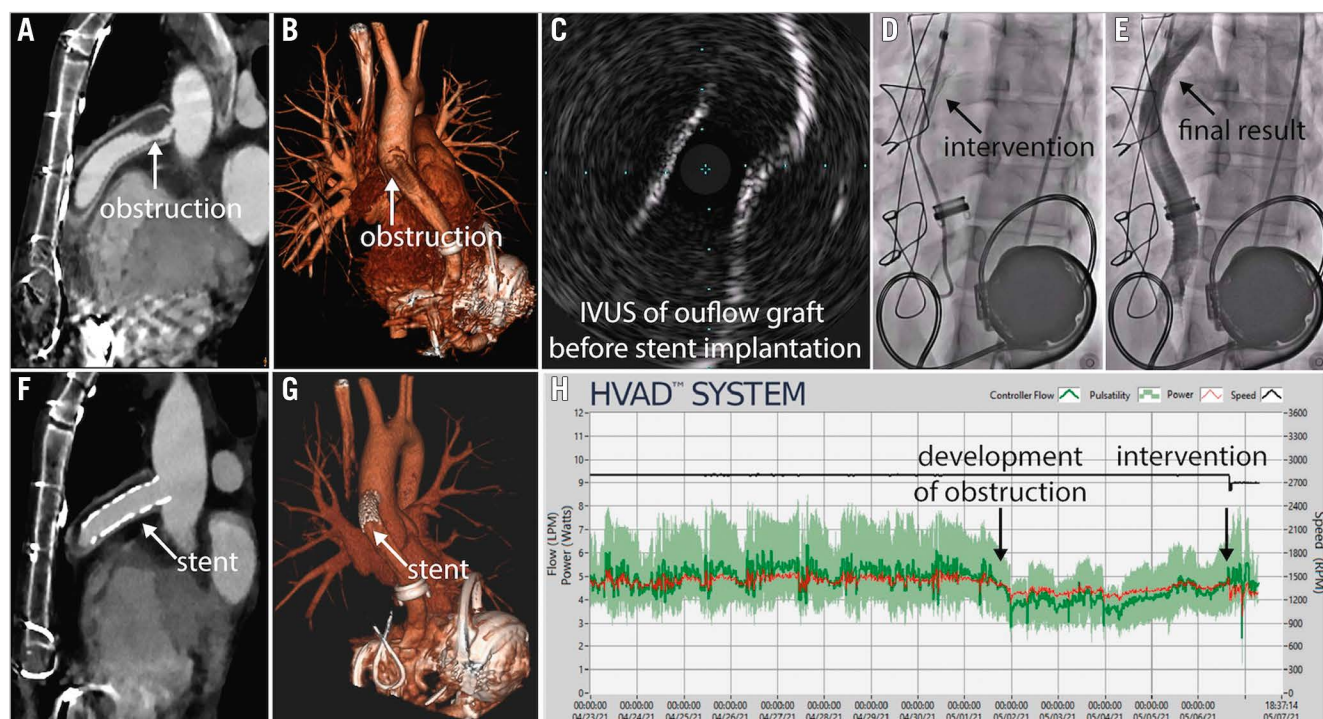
Multimodality imaging and treatment of left ventricular assist device (LVAD) outflow graft obstruction. A 37-year-old man who received a HeartWare ventricular assist device (HVAD) due to a pheochromocytoma with stress-induced, non-reversible cardiomyopathy four years earlier was admitted due to general malaise and low-flow alarms. Computed tomography (CT) angiography demonstrated HVAD outflow graft obstruction (A: white arrow; B: white arrow), which was confirmed with intravascular ultrasound (IVUS; C). Peak-to-peak pressure gradient was 75 mmHg. The stenosis was treated with a balloon-expandable covered stent (D: black arrow; Advanta V12, 12 mm×41 mm), leading to an increase in LVAD flow to 3.5 L/min. The control angiography showed a good procedural result (E: black arrow), which was confirmed by CT (F: white arrow; G: white arrow). The HVAD log showed a sudden decrease in pump flow four days prior to the procedure and restored normal flow following the intervention (H).
